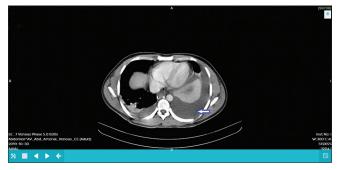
Computed tomography scan of the abdomen suggestive of a large subcapsular splenic hematoma
